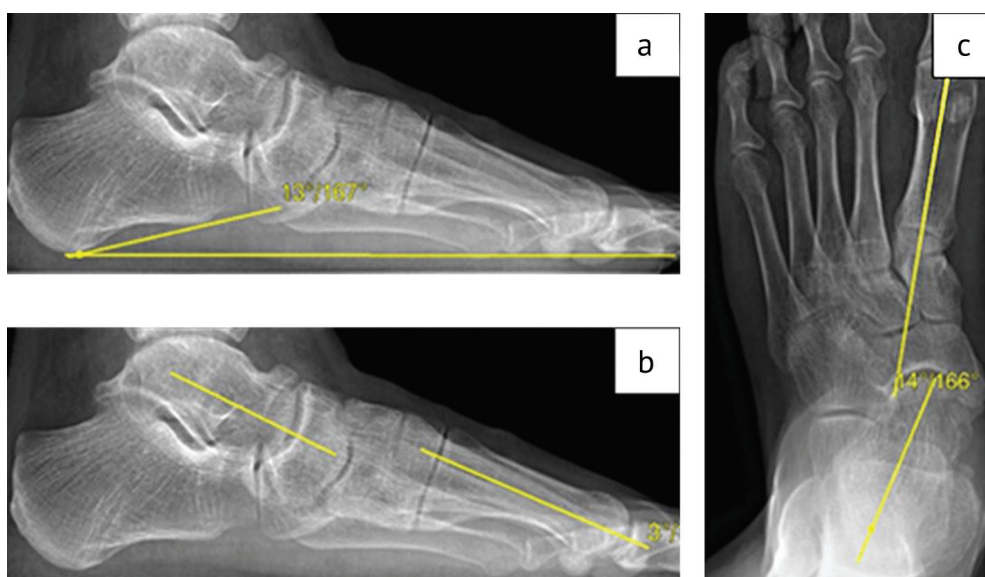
Radiographs of the foot under loading: (a) lateral view, the angle between the calcaneus and the transverse surface; (b) lateral view, the angle between the axis of the talus and the first metatarsal; (c) direct view, the angle between the axis of the talus and the first metatarsal
